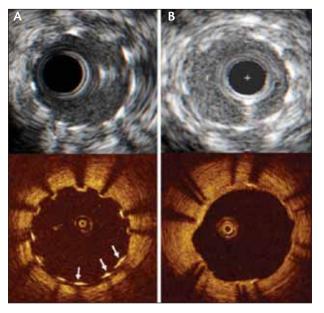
Corresponding IVUS (top) and OCT (bottom) images of a stented coronary artery. OCT images immediately after stent placement show small-sized stent malappositions (white arrows) that IVUS cannot visualize (A). Follow-up OCT images show that the surfaces of the malapposed struts are covered by neointima and therefore may be a benign finding (B). With kind permission from Springer Science+Business Media: *Clin Res Cardiol*, Serial changes of minimal stent malapposition not detected by intravascular ultrasound: follow-up optical coherence tomography study, 99, 2010, 639–644, Kim et al, Figure 2.⁴⁹
